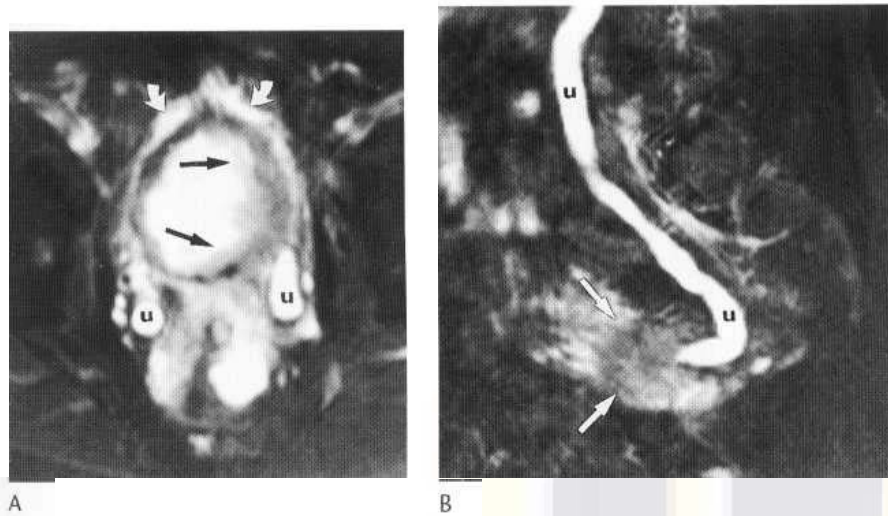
Extensive stage T3b bladder tumour (straight arrows) with bilateral obstructive uropathy on (A) transverse and (B) parasagittal T₂-weighted spin-echo (SE 3500/100) images with fat suppression. The dilated ureters (u) are clearly shown to contain high-signal urine with no spread of the transitional cell carcinoma into the ureters. This was suggested on CT (not shown). There is also ascites (curved arrows) present.
